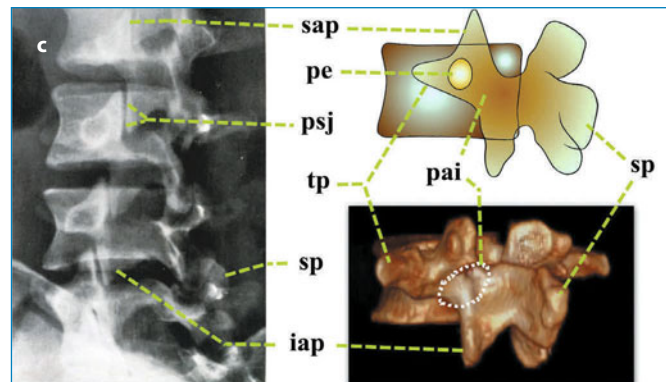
Plain radiography of lumbosacral segments in anteroposterior (a), left lateral (b) and oblique projections with three-dimensional volume-rendered multidetector row CT reconstruction of the lumbar vertebra (c). Inter-apophyseal laminar space (*ials*); transverse process (*tp*); twelfth rib (12th rib); pedicle (*pe*); intervertebral disk space (*ivs*); spinous process (*sp*); inferior articular process (*iap*); superior articular process (*sap*); pars interarticularis (*pai*); vertebral body (*vb*); neural foramen (*nf*); posterior spinal facet joint (zygapophyseal) (*psj*)
